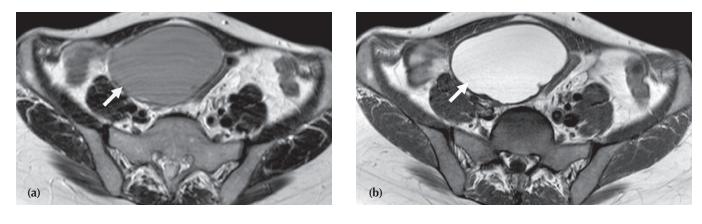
MRI of left ovarian dermoid cyst. (a) Axial  $T_2$ -weighted image of the pelvis. There is a 7 cm high  $T_2$ -signal intensity cystic ovarian mass with central soft tissue. (b) Axial  $T_1$ -weighted image showing the cystic ovarian mass has high  $T_1$ -signal intensity material. (c) Axial  $T_1$ -weighted and fat-saturated image. This shows loss of the high  $T_1$ -signal intensity after application of fat saturation sequences indicating the presence of fat in the cystic ovarian mass. This detection and characterisation of fat in cystic ovarian masses is typical of ovarian dermoid cysts.
